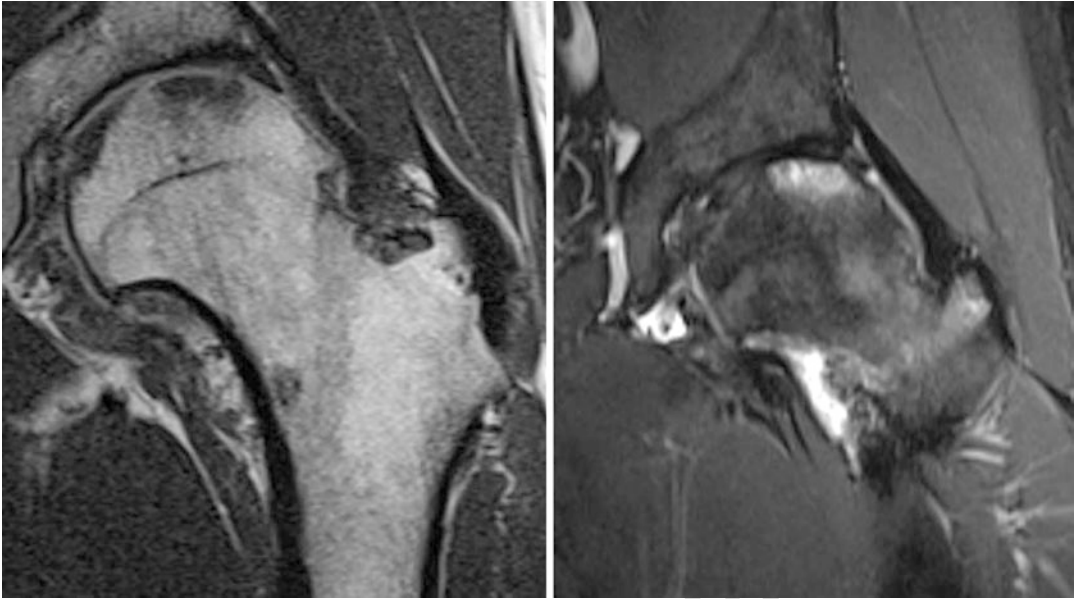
T1- and T2-weighted MRI with gadolinium of the same patient showing big osteochondral lesions and labral tear
